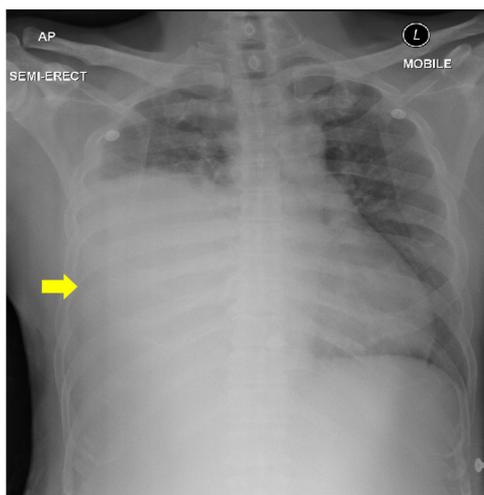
Chest X-ray showed the opacities of the right mid and lower zone (yellow arrow) with trachea deviated to the left.
